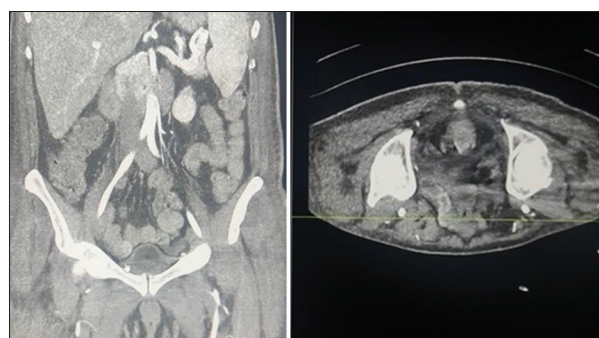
Computed tomography -small bowel (distal ileum) thickening
